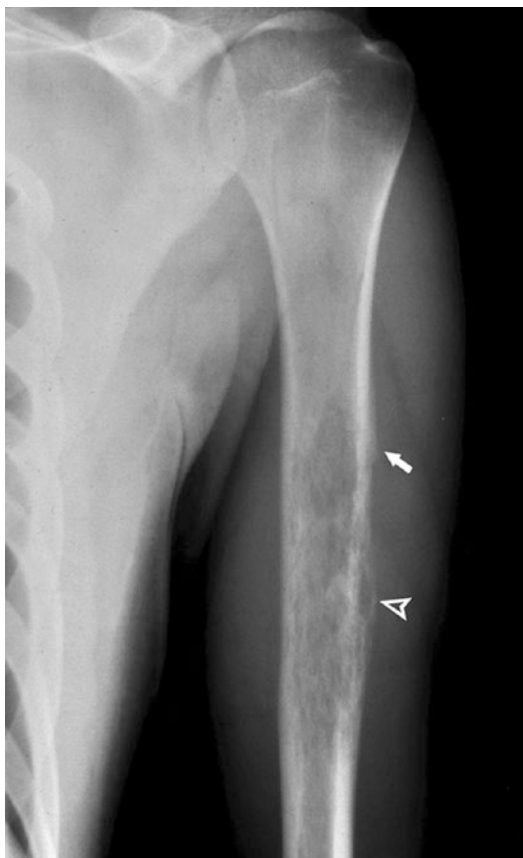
Ewing sarcoma: 20-year-old male with shoulder pain. Radiograph demonstrates a diaphyseal lesion with moth-eaten to permeative (arrowhead) destruction of the cortex and medullary space. There is an aggressive periosteal reaction (arrow)
